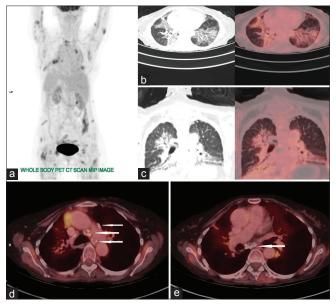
(a) F-18 FDG PET CT scan in maximal intensity projection (MIP) view shows pathological fluorodeoxyglucose uptake in bilateral lung fields and mediastinal lymph nodes and numerous sites of linear and patchy FDG uptake in the skeletal muscles and cutaneous tissue (b and c) are axial CT and fused PET CT images demonstrating metabolically active symmetric peribrochovascular and perihilar ground-glass opacities and consolidative lesions in bilateral lung fields. (d and e) show calcified mediastinal lymph nodes (white arrows)
